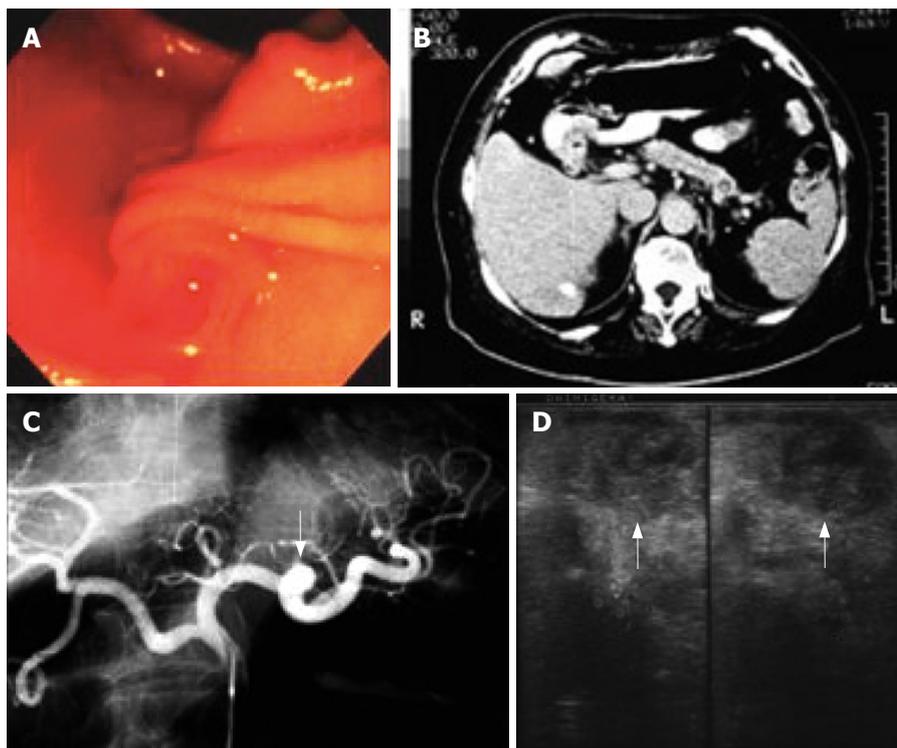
Case 1. Pseudoaneurysm of splenic artery communicating with pancreatic duct. A: Endoscopy reveals bleeding from papilla of Vater; B: CT scan shows a cystic mass at tail of pancreas; C: Angiography identifies aneurysms at distal portion of splenic artery and right hepatic artery (arrow); D: Operative ultrasonography demonstrates a low echoic mass at body of pancreas suspected as a hematoma (arrow).
